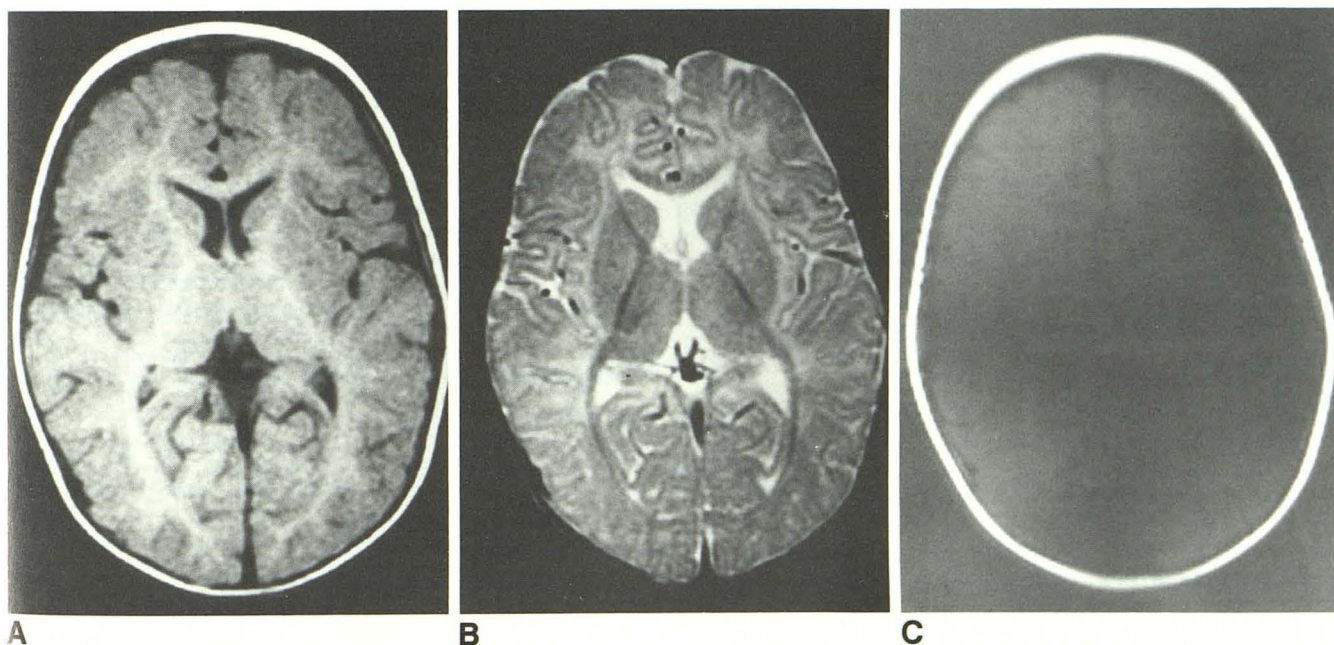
A–C, 5-month-old child. Axial T2-weighted, 600/20 (A), and T2-weighted, 2500/80 (B), images. Internal capsule and optic radiation appear myelinated while myelination in the frontal, temporal, and occipital white matter is still progressing. Chemical shift fat-water image, 1000/25
